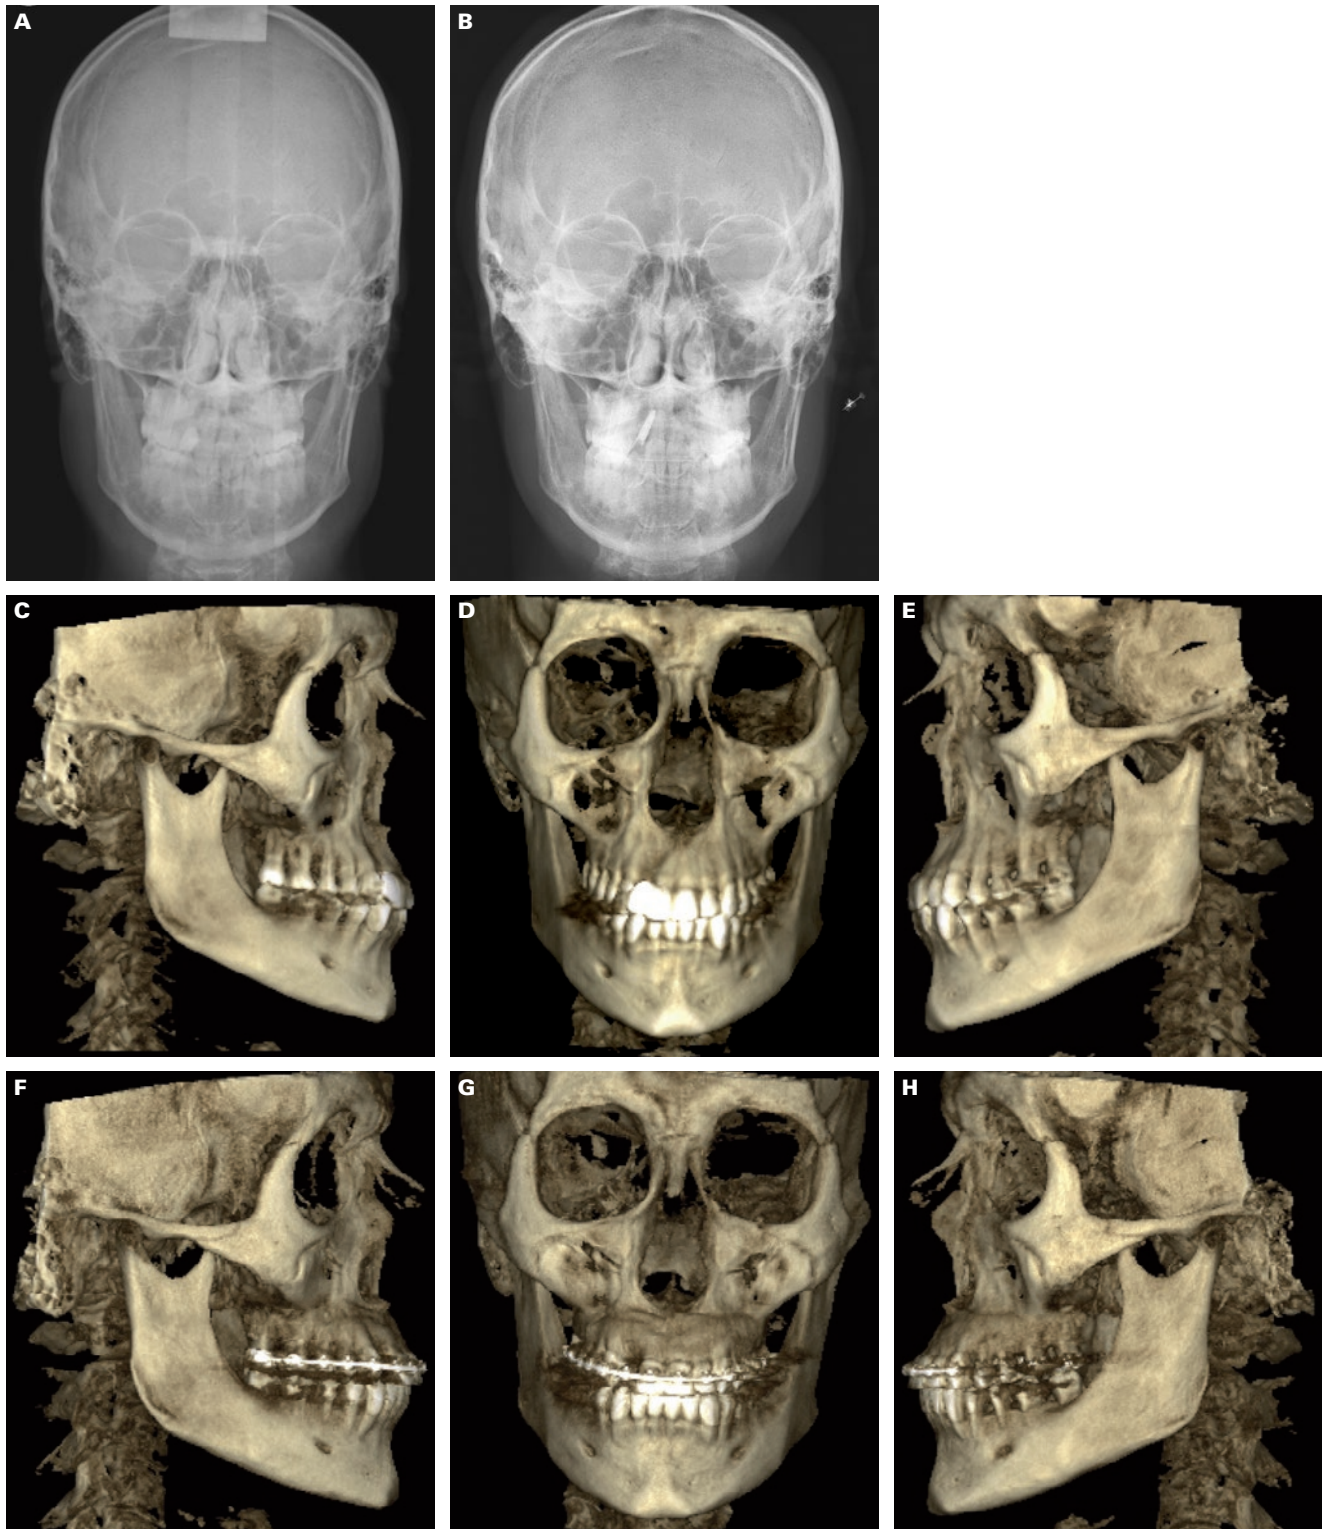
A-H. Posteroanterior Cephalograms before and after treatment to show the transverse changes in both upper and lower arches. The CBCT images at the beginning of treatment and right before debonding show the amount of alveolar bone created in the upper arch with the alveolar corticotomy and the bone graft.
